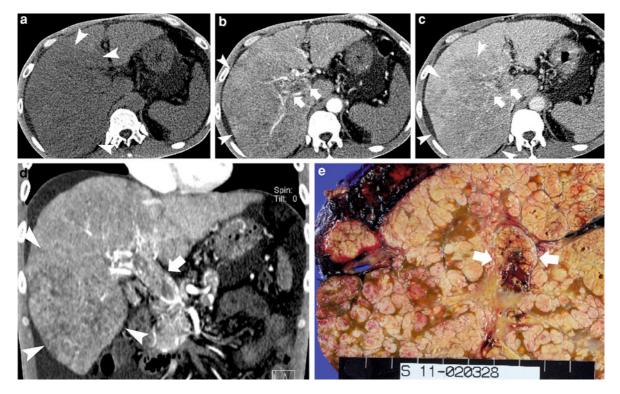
Diffuse HCC with portal vein thrombosis. a Precontrast CT scan shows that the right lobe is hypoattenuated (*arrowheads*) compared with the left lobe. b Arterial phase CT scan shows enhancing thrombus (*arrows*) within the portal vein that appears expanded. The presence of tumor thrombus suggests an underlying mass. Patchy enhancement is noted in the right lobe mass lesion (*arrowheads*). *c* Portal phase CT scan
